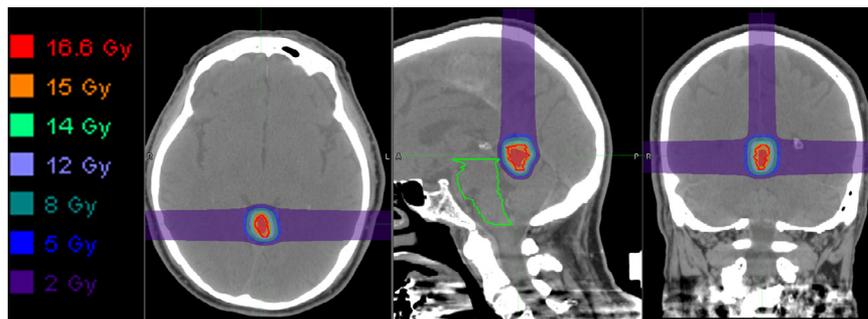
Axial, sagittal, and coronal views of CT image of AVM with dosimetry planning for stereotactic proton beam radiosurgery for obliteration. AVM, arteriovenous malformations.
